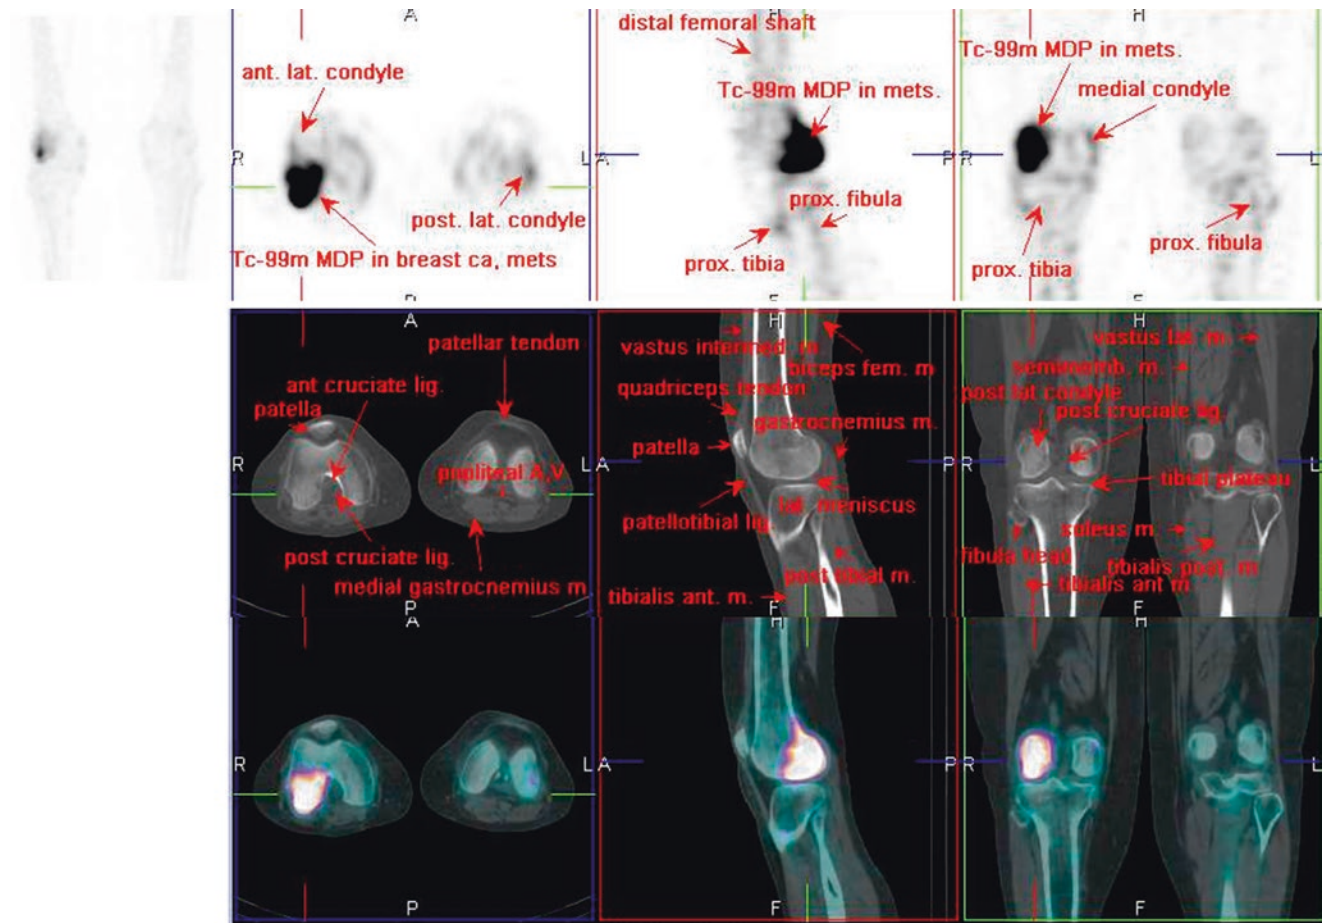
^{99m}Tc-MDP SPECT/CT
